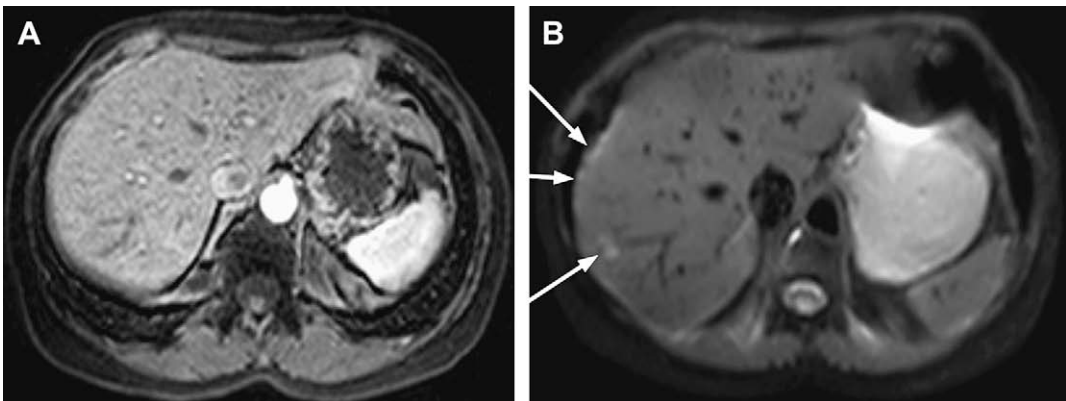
60-year-old woman with breast cancer. Arterial phase gadolinium-enhanced 3D FSPGR image (A) is unremarkable without evidence of liver metastasis. T1-weighted, T2-weighted, and portal venous phase gadolinium-enhanced images (not shown) were also normal. Breath-hold DW image (B) b-value 20 s/mm² shows small subcapsular and parenchymal liver metastases (arrows). Findings were confirmed by biopsy. This case demonstrates the sensitivity of DW imaging to small tumors. The "black blood" appearance of the DW image facilitates depiction of small perivascular tumors.
